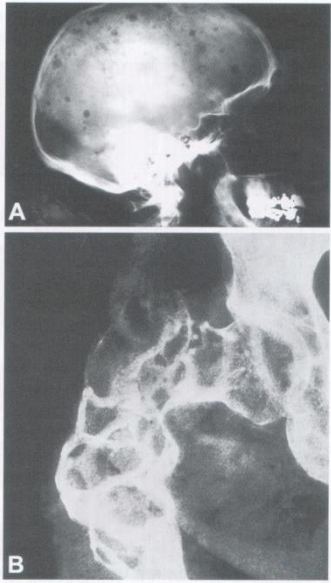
Plasma cell myeloma. Radiographs of skull (A) and femoral head (B) demonstrate multiple lytic bone lesions.
